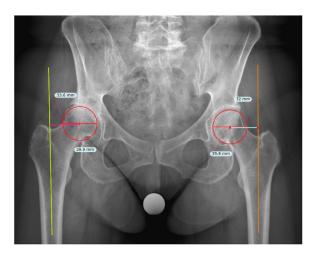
Preoperative AP pelvis radiograph demonstrating the measurement of femoral offset using the center of the femoral head and anatomical axis of the femur.
